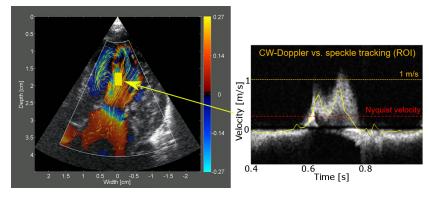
Validation of the velocity estimates from speckle tracking towards continuous wave (CW) Doppler from a small region-of-interest (ROI).
